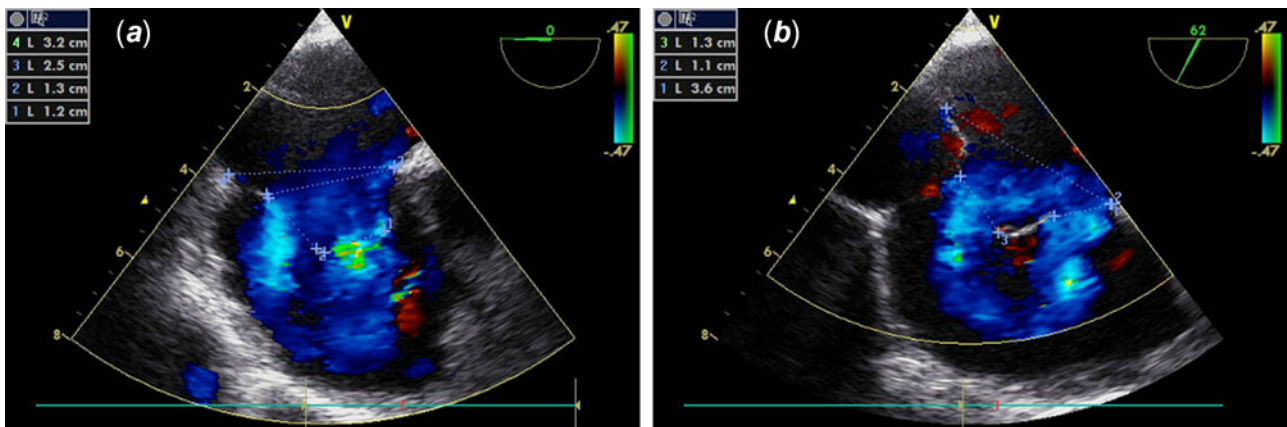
TOE views showing a multi-fenestrated aneurysmal-type inter-atrial septum with a 25-mm long aneurysmal base at 0° view and two major adjacent holes on colour Doppler view with the diameters of 12 and 13 mm (a). Aneurysm base measured 32 mm at 62° view (b). TOE = Trans-oesophageal echocardiography.
